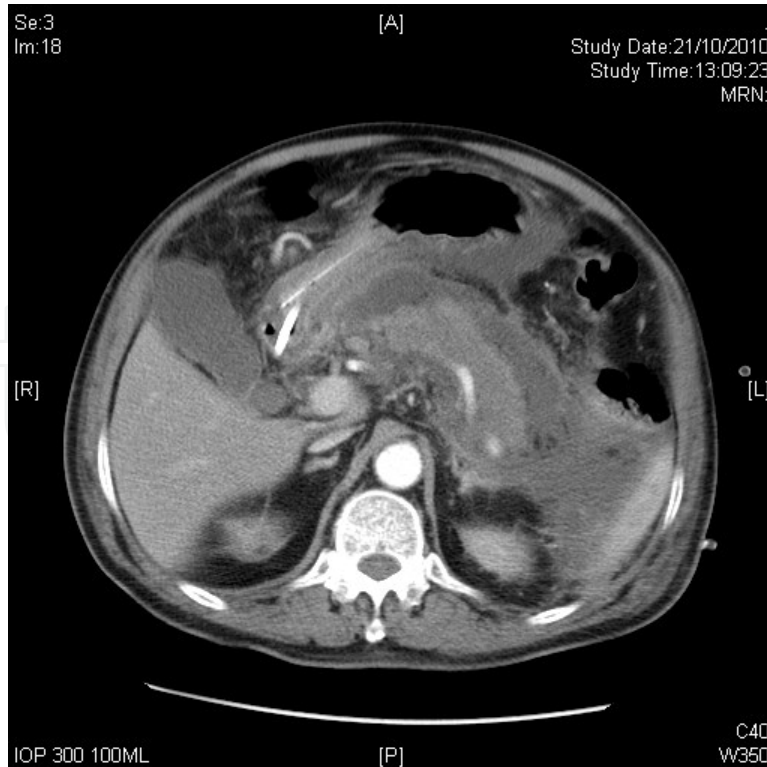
This CT film of a patient with pancreatic necrosis characterized by non-enhanced pancreatic parenchyma.
